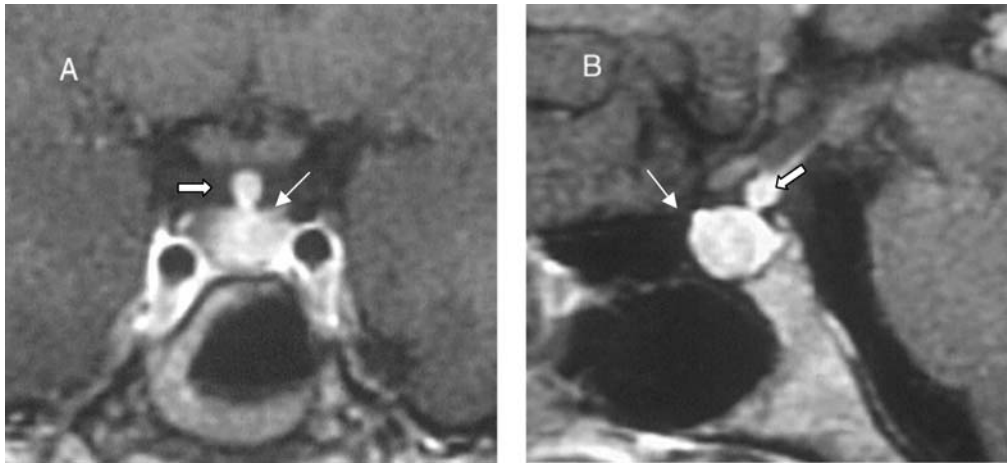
Gadolinium (Gd)-enhanced coronal (A) and sagittal (B) T1 MRI of the sella turcica of a patient with LIPH. Narrow arrows point the markedly enhanced enlarged pituitary. Bold arrows point to a very thickened pituitary stalk
